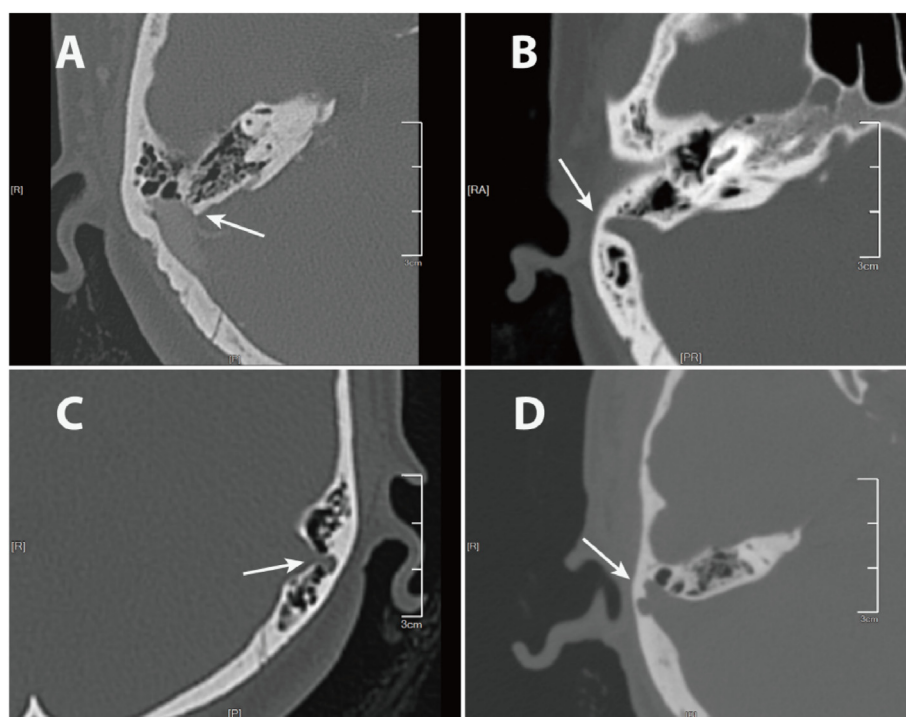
Pre-operative CTA images of the 4 study patients (arrow). A: Bone wall defect of the right sigmoid sinus (No. 1). B: Bone wall defect of the right sigmoid sinus and protrusion of the sigmoid sinus into the bone cortex (No. 2). C: Left sigmoid diverticulum (No. 3). D: Right sigmoid diverticulum (No. 4).
